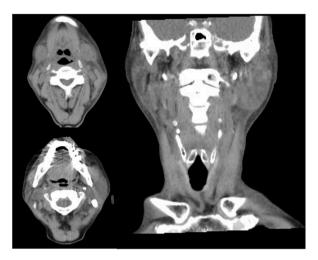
Non-contrast CT of the neck showed bilateral submandibular and parotid gland swelling.
